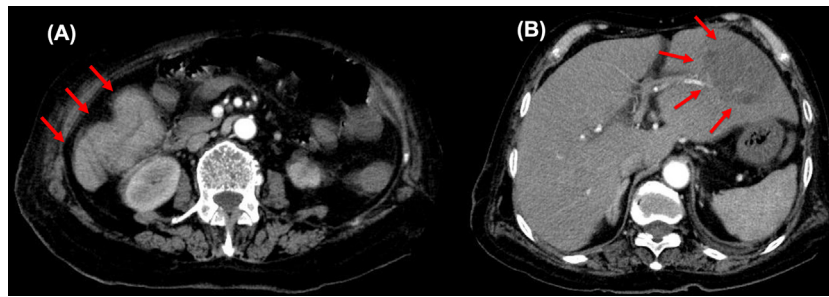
Enhanced CT scan demonstrates a transverse colon tumor (A) with liver abscess (B).
